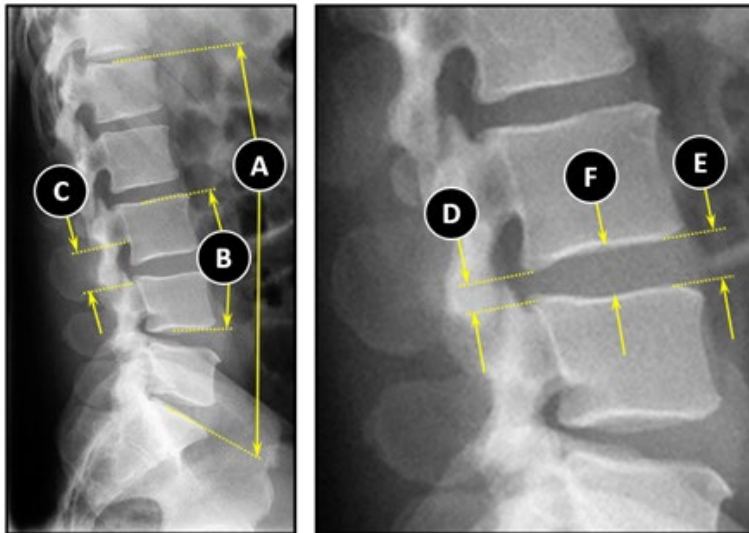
Plain film lateral radiographic images of the lumbar. (A) Lumbar Lordosis=LL, (B) Focal Lordosis=FL, (C) Foraminal Height=FH, (D) Posterior Disc Height=PH, (E) Anterior Disc Height=AH, (F) Disc Height=DH
